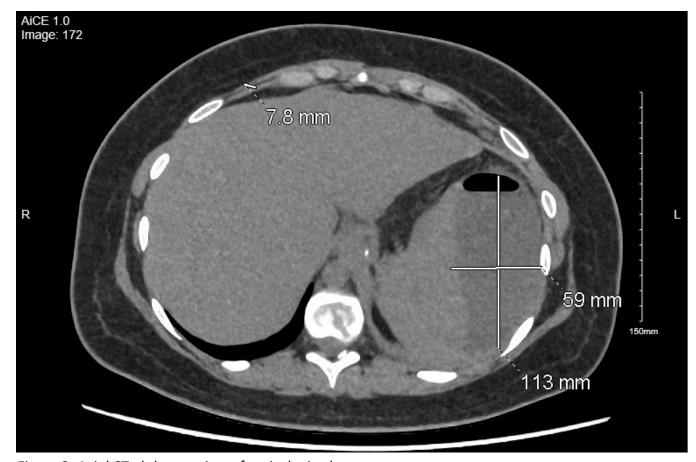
Axial CT abdomen view of perisplenic abscess
